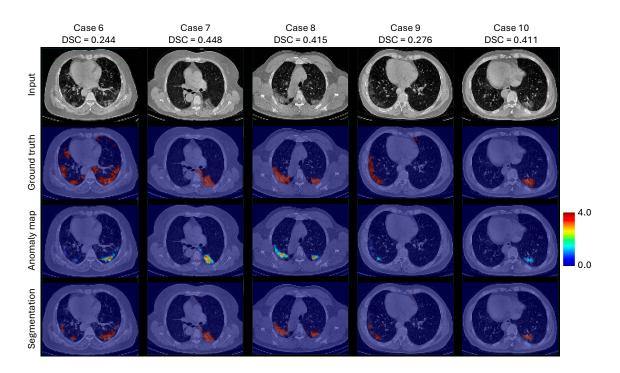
Additional Abnormality localization results on the Covid-19 CT dataset.
